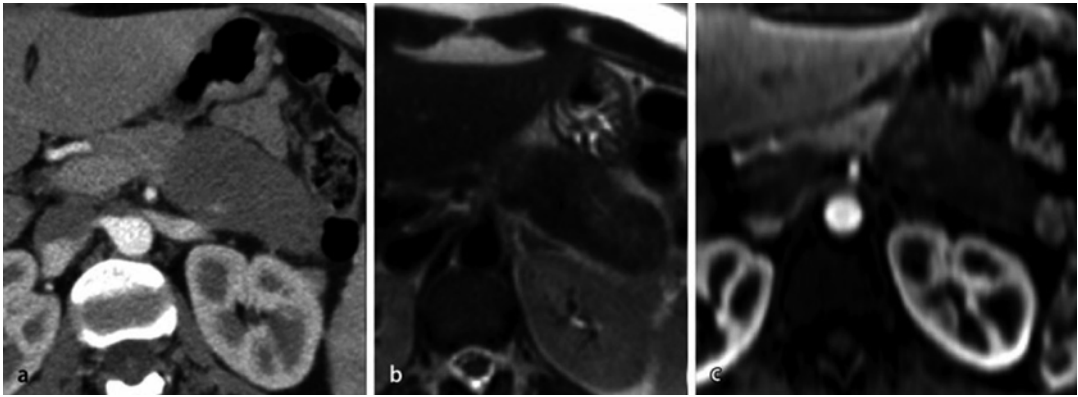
Imaging in autoimmune pancreatitis. (a) MDCT with contrast and a hypodense swelling of the pancreatic tail. (b) T2-weighted MRI, demonstrating the segmental vanishing of the MPD and a reduction of signal. (c)
